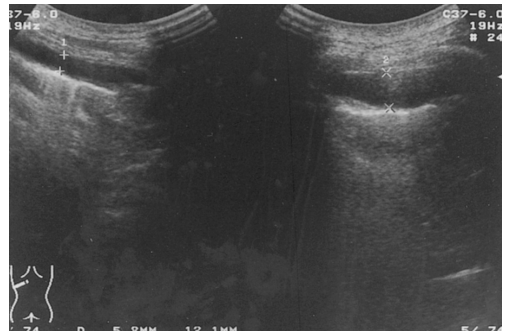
Sonograms show a thin fluid layer (6 mm) visible during inspiration (left image, calipers). Pleural effusion became much more apparent during expiration and allowed the reliable diagnosis (right image, calipers).
